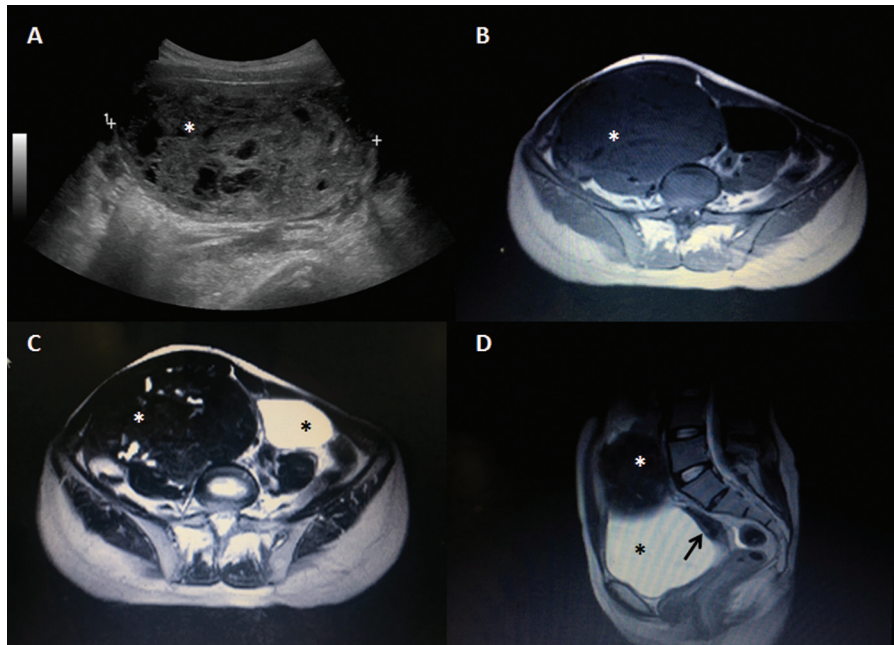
(a) Transabdominal US image showing a solid near-homogenous isoechoic mass. (b, c) Axial T1W and T2W MRI showing a large isointense-to-hypointense mass (white asterisk) in the right lower abdomen and the adnexal region compressing the urinary bladder (black asterisk). (d) Sagittal T2W MRI showing a small hypoplastic uterine tissue/Mullerian remnant (black arrow) behind the urinary bladder (black asterisk)
